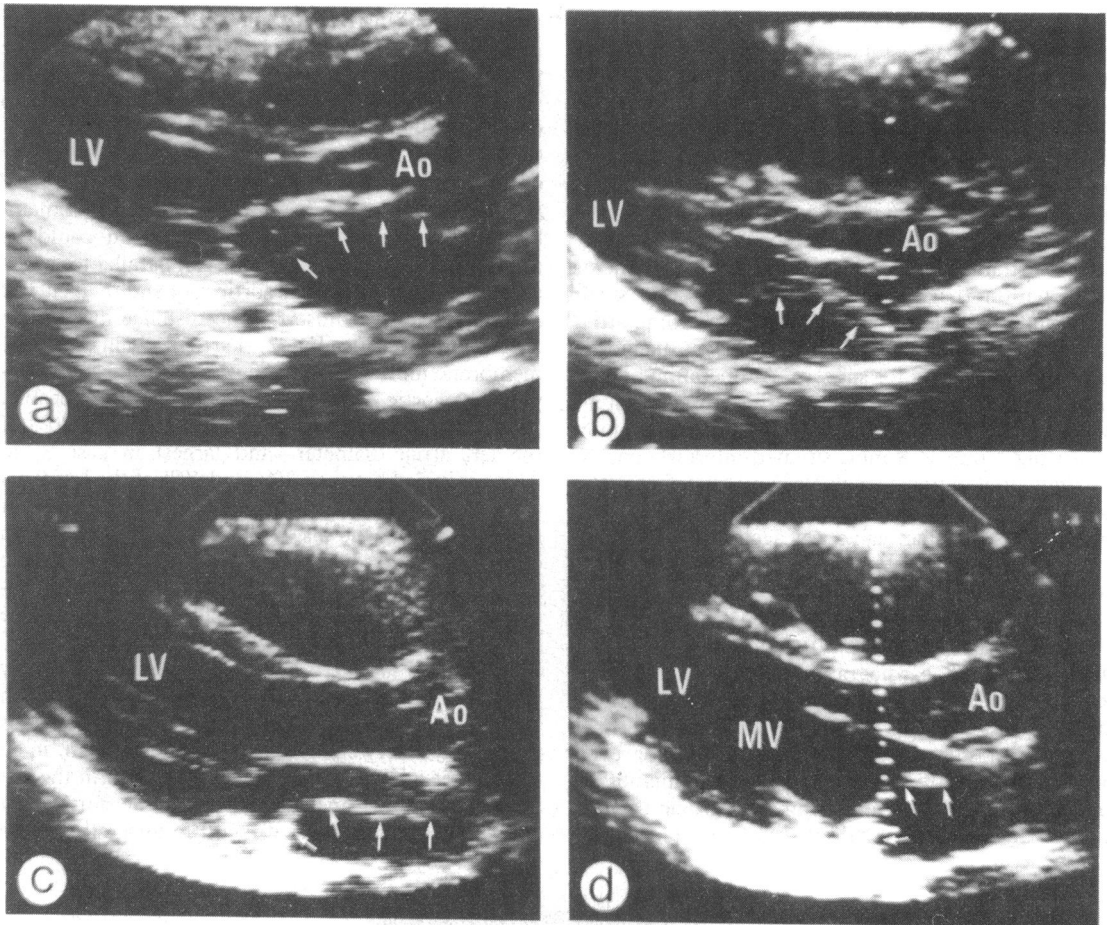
Cross sectional echocardiographic appearances in the parasternal long axis view. (a) Case 1: the abnormal membrane within the left atrium is marked by small arrows; in this case the membrane was very thin. Although it is difficult to demonstrate on a freeze frame the movement towards the mitral valve funnel in diastole made it easier to identify the membrane as a definite intra-atrial structure when viewed in real time. (b) Case 2: the massively enlarged right ventricle distorts the appearances in this view causing the interventricular septum to bulge into the left ventricular outflow tract virtually touching the anterior leaflet of the mitral valve. The abnormal membrane (small arrows) is thicker and easily seen. (c) and (d) show the appearances in case 3 in end systole and diastole respectively. The abnormal membrane (small arrows), which again is fairly thick, moves anteriorly, closer to the aortic root during diastole. In all three cases the proximal left atrium—that is, the part of the left atrium receiving the pulmonary veins—is posterior and inferior to the distal left atrium, with the latter creating a recess behind the aortic root. Ao, aorta; MV, mitral valve; LV, left ventricle.
